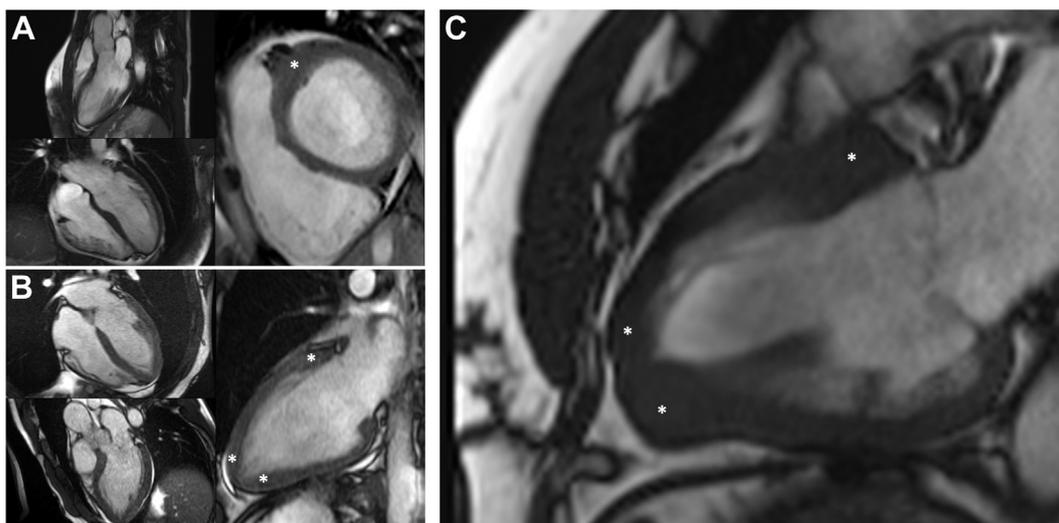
Recognition of subtle hypertrophic cardiomyopathy using cardiac magnetic resonance in 3 different patients. (A) Mild hypertrophic cardiomyopathy phenotype with focal basal anterior wall hypertrophy (asterisk) that was nondiagnostic using echocardiography. (B) Young patient with marked T-wave inversions across the precordial leads. Echocardiogram was reported as unremarkable, cardiac magnetic resonance revealed subtle left ventricular thickening (asterisks) at the apex relative to the mid ventricle. Note that there is also slightly disproportionate thickening of the basal segment (asterisk). (C) The same phenomenon of apical/basal hypertrophy (asterisks) is more readily appreciated in this third example.
